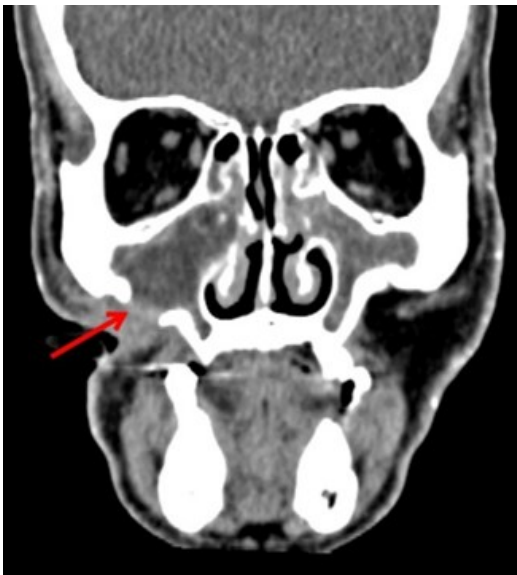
Contrast-enhanced computed tomography of the paranasal sinuses (CECT PNS) revealed heterogeneous soft-tissue density involving the maxillary sinuses, with erosion of the inferolateral wall of the right maxillary sinus and right maxillary process (red arrow: site of bony erosion)
